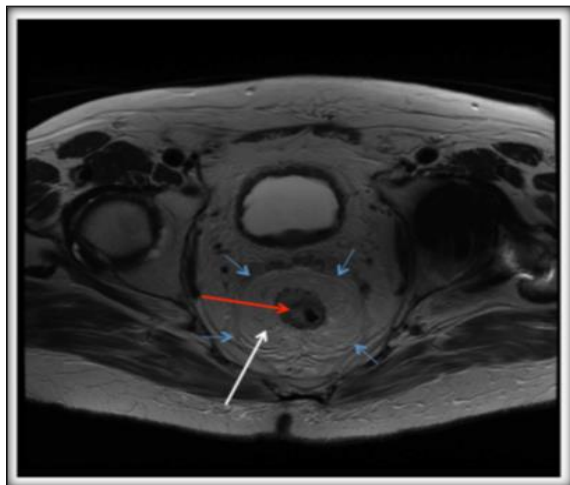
Anatomy on MRI axial image. Blue arrows outline the mesorectal fascia, white arrow mesorectal fat and the red arrow shows the rectum
